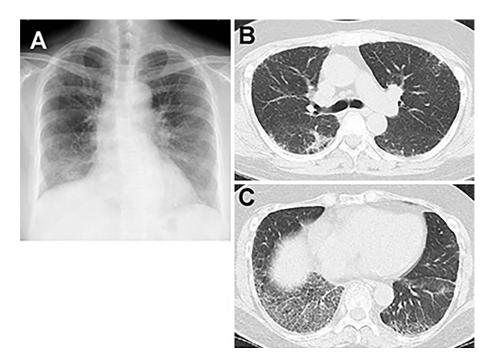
Imaging findings at the time of the initial diagnosis at another hospital. (A) Chest radiography showing ground-glass opacities and reticular shadows on both sides, indicating a loss of lung volume. (B, C) Computed tomography showing reticular shadows and ground-glass opacities in the peripheral regions of the upper and lower lobes of both lungs and especially in the lower lobes.
